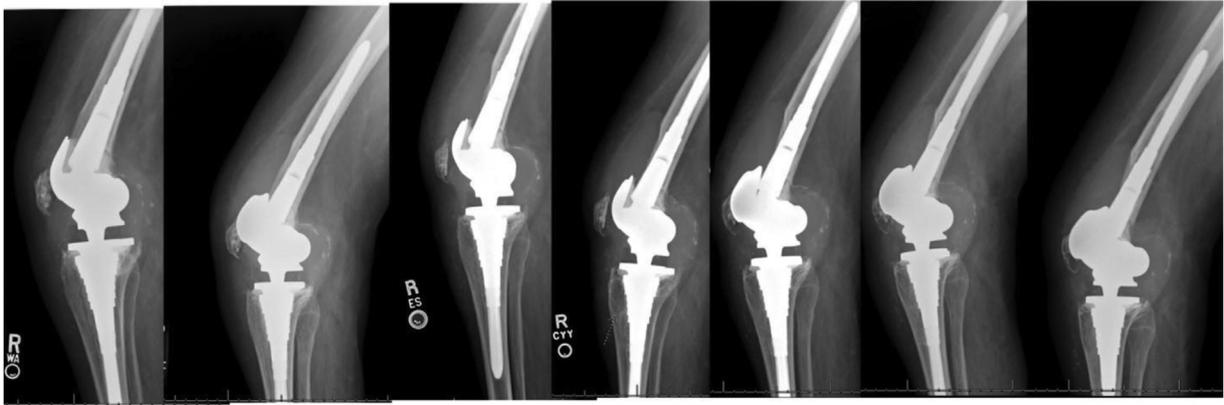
Serial lateral knee radiographs at 6 weeks, 1 year, 2 years, 3 years, 4 years, 5 years, and 6 years follow-up demonstrating a large effusion in the supratellar pouch along with adjacent progressive bone loss of the anterior cortex of the distal femur and an anterior tibial cyst, which became noticeable at year 2.
